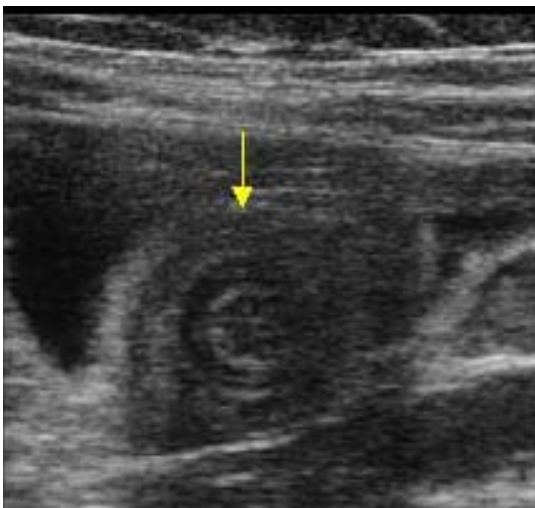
a:Ultrasound Abdomen -Intussusception(target sign
